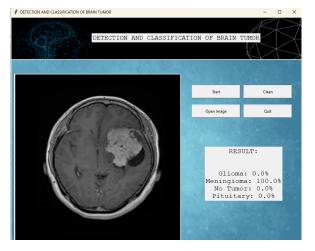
Prediction for a Meningioma MRI image from [5].
